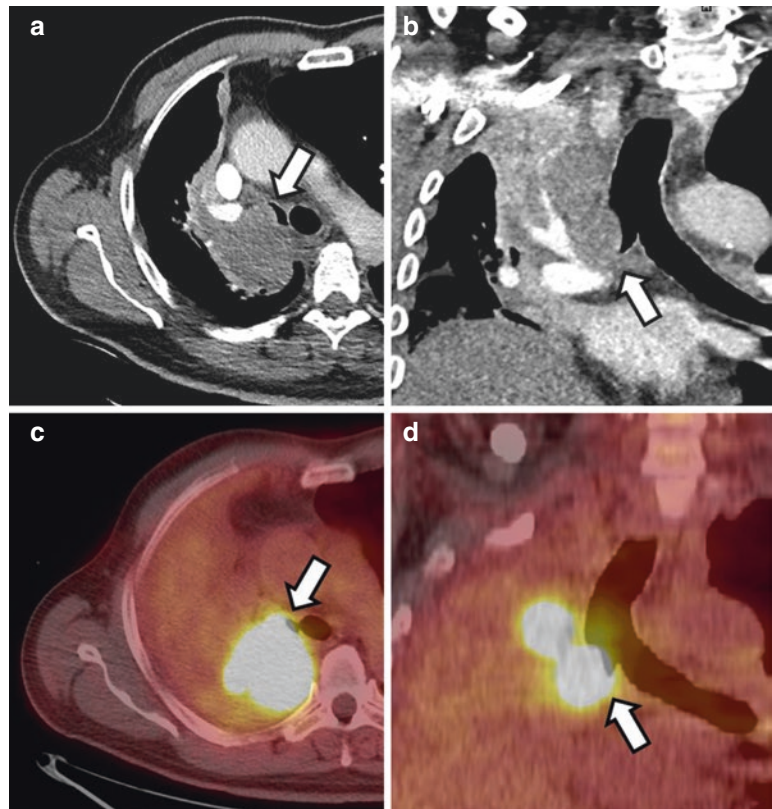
Infiltration of the main bronchus in a 58-year-old man with pulmonary squamous cell carcinoma stage cT3 cN2 cM1b. (a, b) Contrast-enhanced CT; (c, d) FDG-PET/CT with non-enhanced CT acquired 2 days after the initial CT exam. A hypermetabolic mass (arrows) is noted invading the right main bronchus with a remaining distance of less than 2 cm to the carina. Note that the distance threshold of 2 cm separating the stages T2 and T3 in the 7th edition is not included anymore in the 8th edition of the TNM classification
